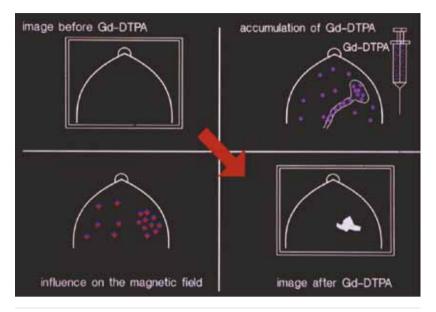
Overall contrast enhancement (uptake) gives functional information about the pathophysiology of the underlying tissue. Increased and early uptake, as observed in 95% of invasive breast cancers and in 50-60 % of DCIS is caused by increased vascularity, vascular permeability and increased interstitial space. Other studies have shown that growth of invasive tumours beyond a size of 2-3 mm requires such increased and changed vascularity. Growth of such tumour vessels is caused by so-called growth factors, which are produced by the tumours. Approximately half of the malignant tumours also demonstrate an early washout. If present, this may be an important indicator of malignancy. Until today the above-mentioned observations constitute the basic information, which can be gained from contrast-enhanced breast MRI.
